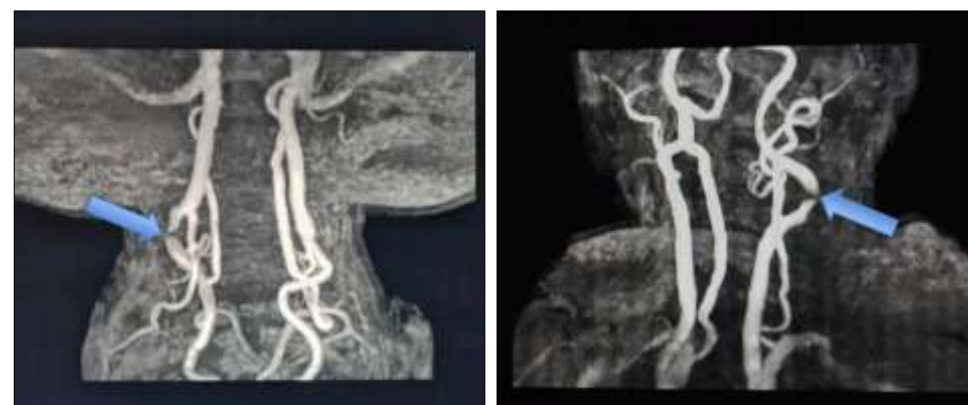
MRI Angiography of Necks Vessels Showing Severe Stenosis of Left Proximal Ica Artery (Marked as Blue Arrow)
